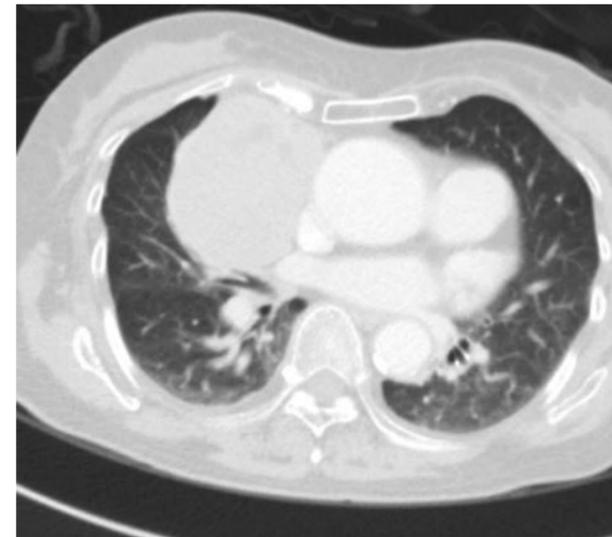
Selected axial CT slice, lung windows.
